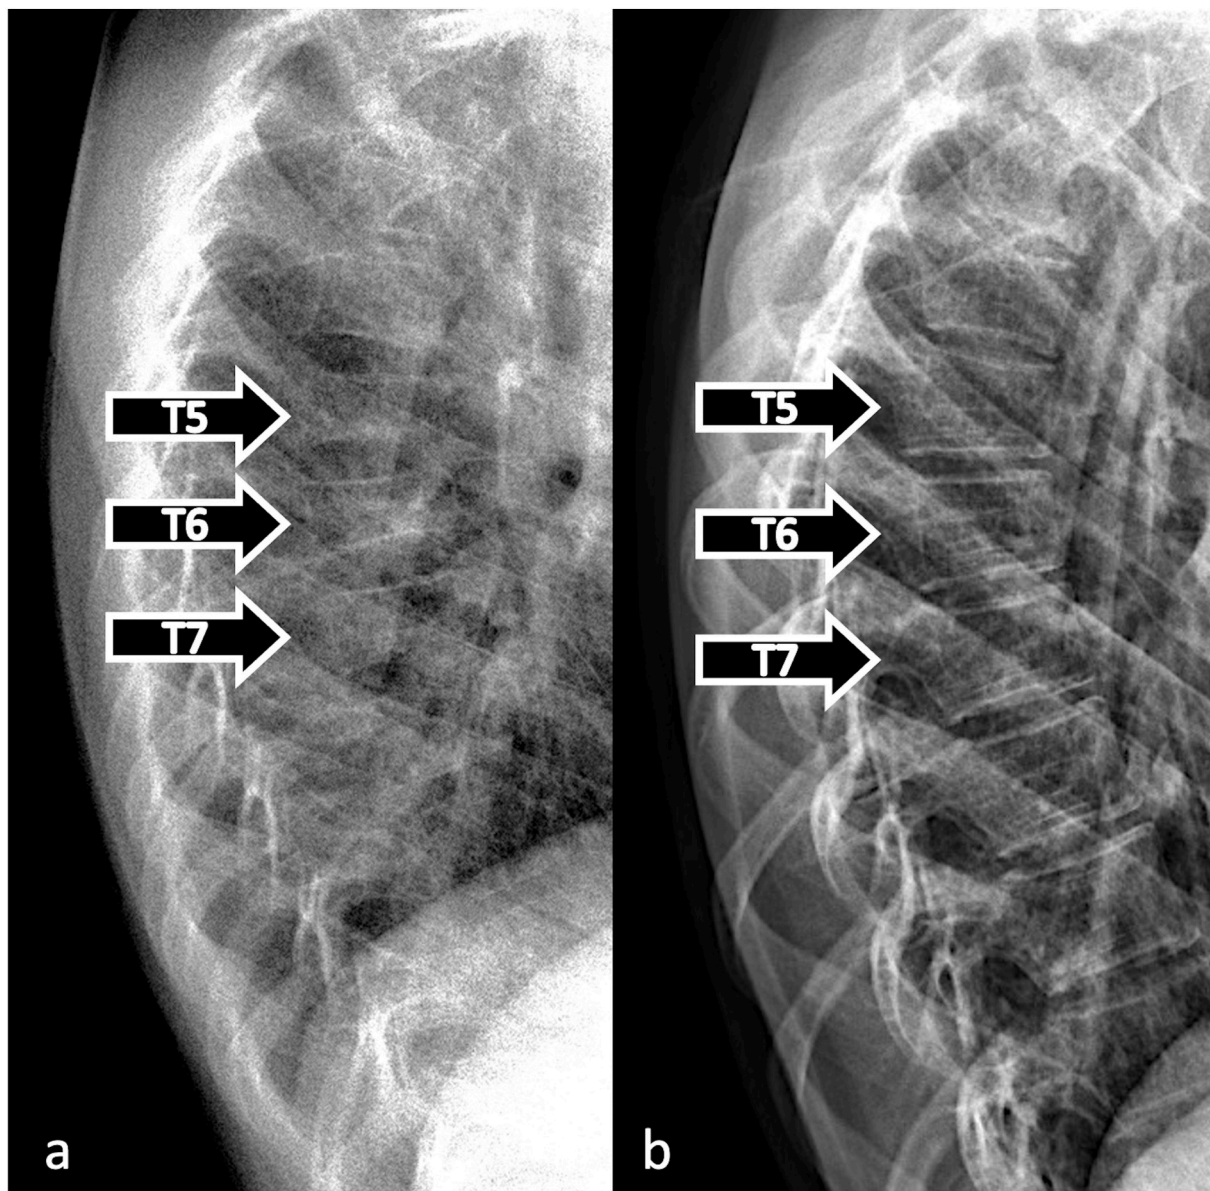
Lateral spinal radiographs at the age of 6 years (a) and 17 years (b). At the age of 6 years wedging VF are visible at T5 (GSQ grade I) and concavity VF at T6 (GSQ grade II) and T7 (GSQ grade I). The fractures are in the known “hot spot” – the mid-thoracic region. All three VF had reshaped substantially by the age of 17.
